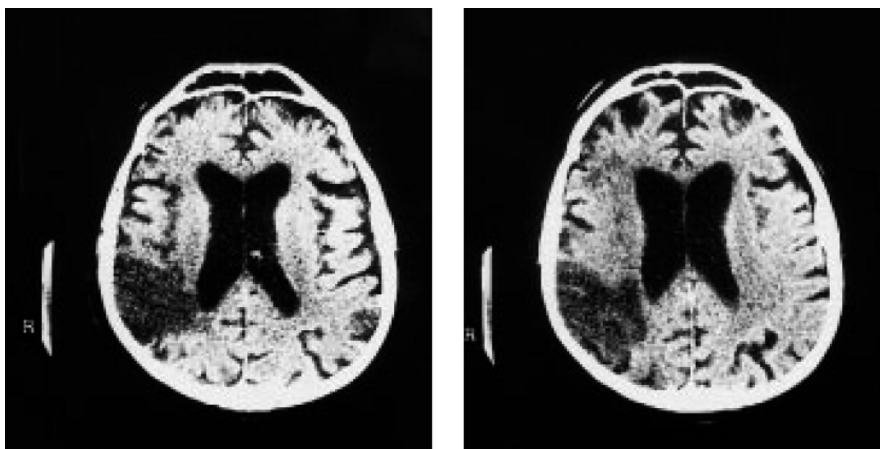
CT scan of Fellini 1 week after the stroke showing the large lesion encroaching upon the temporoparietal regions of the right hemisphere. The CT scan was performed at the Hospital of Rimini [from Cantagallo and Della Sala, 1998, with kind permission].
